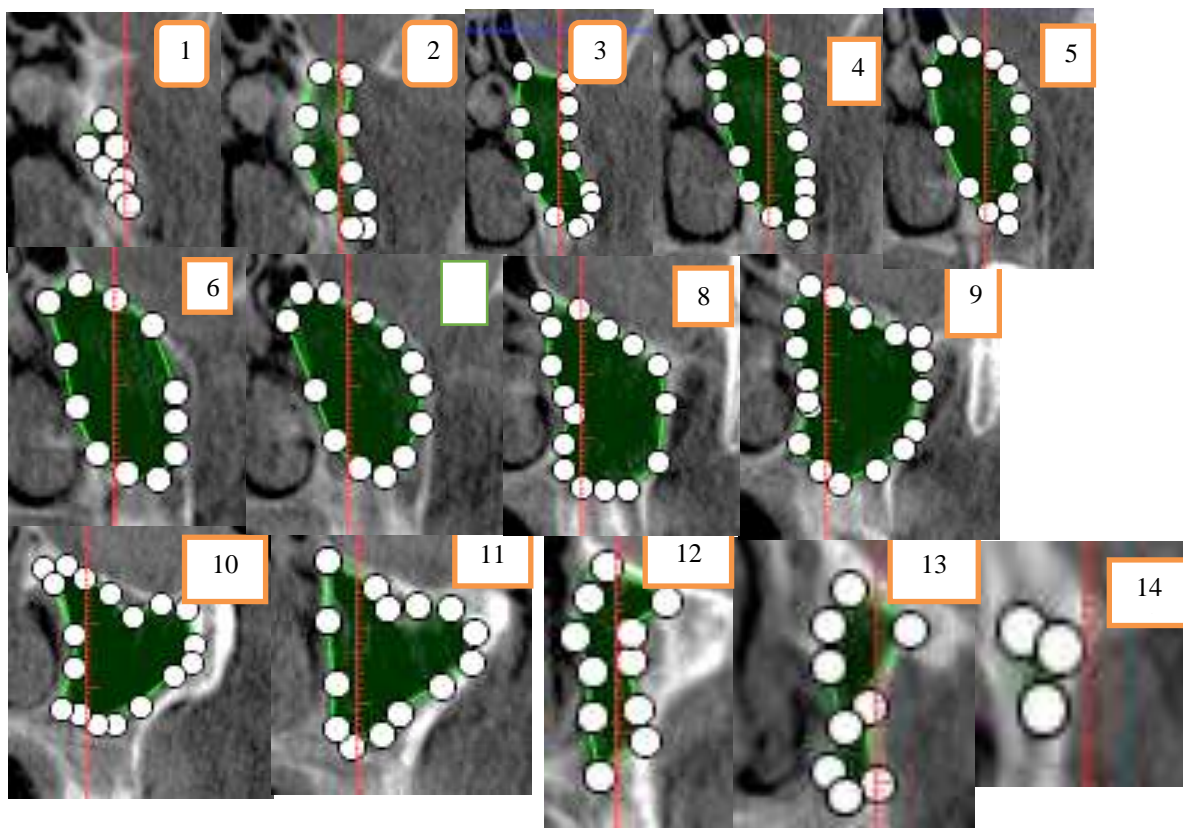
A sample of the outlined maxillary sinus in different CBCT slices.1 to 14 from anterior to posterior
